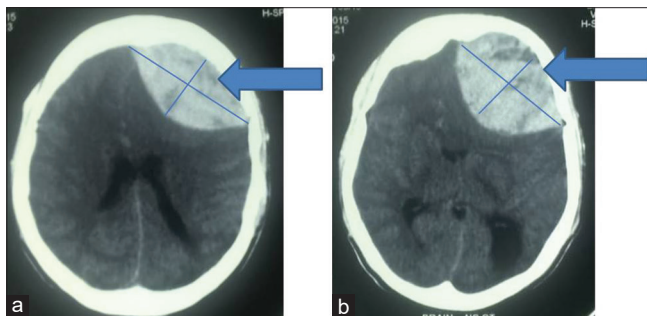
(a and b) Axial views of non-contrast computed tomography of the brain showing left extradural hematoma (arrow)
